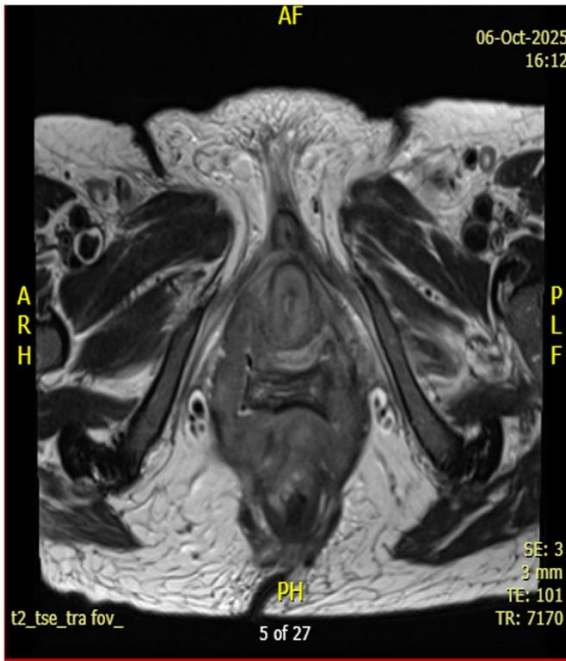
MRI axial view showing extensive abnormal soft tissue.
